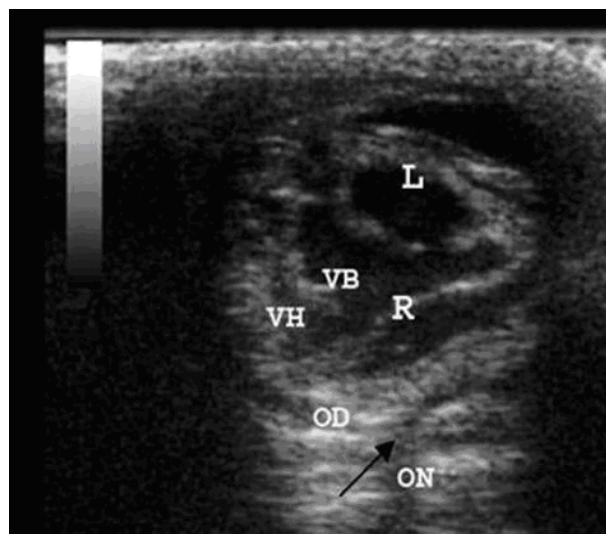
Ultrasonography image (10 MHz linear probe) showing misshapen eye globe with vitreous hemorrhage (VH) inferiorly. The optic nerve head (ON) is obscured by the overlying hemorrhage. Retina (R) is completely detached. The optic nerve is not reaching the optic disc (OD) and an area of hypoluency is seen anteriorly (arrow)
